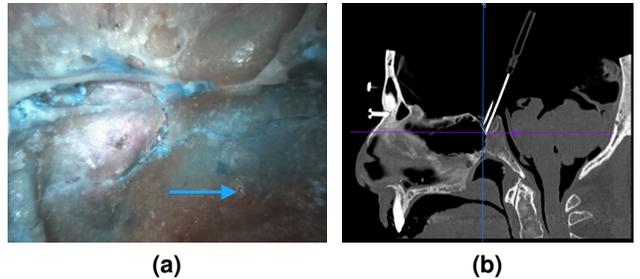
A 23 Ga needle tip in optical (left) and CT (right) images. These provide a fiducial that can be localized with sub-millimeter precision in both video and CT for gold standard registration.
